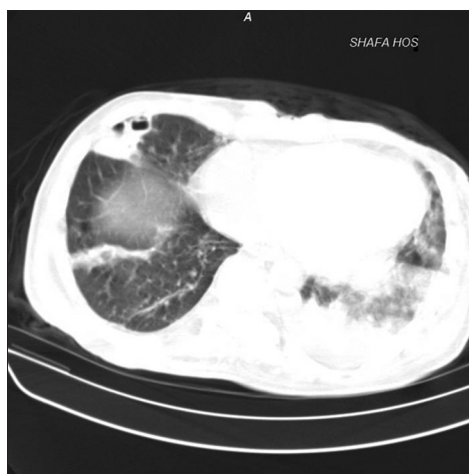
Computed tomography scan of the lungs showing two cavitary lesions in the right middle lobe. There is a patchy consolidation in the left lower lobe. Pleural effusion on the left side is also seen
